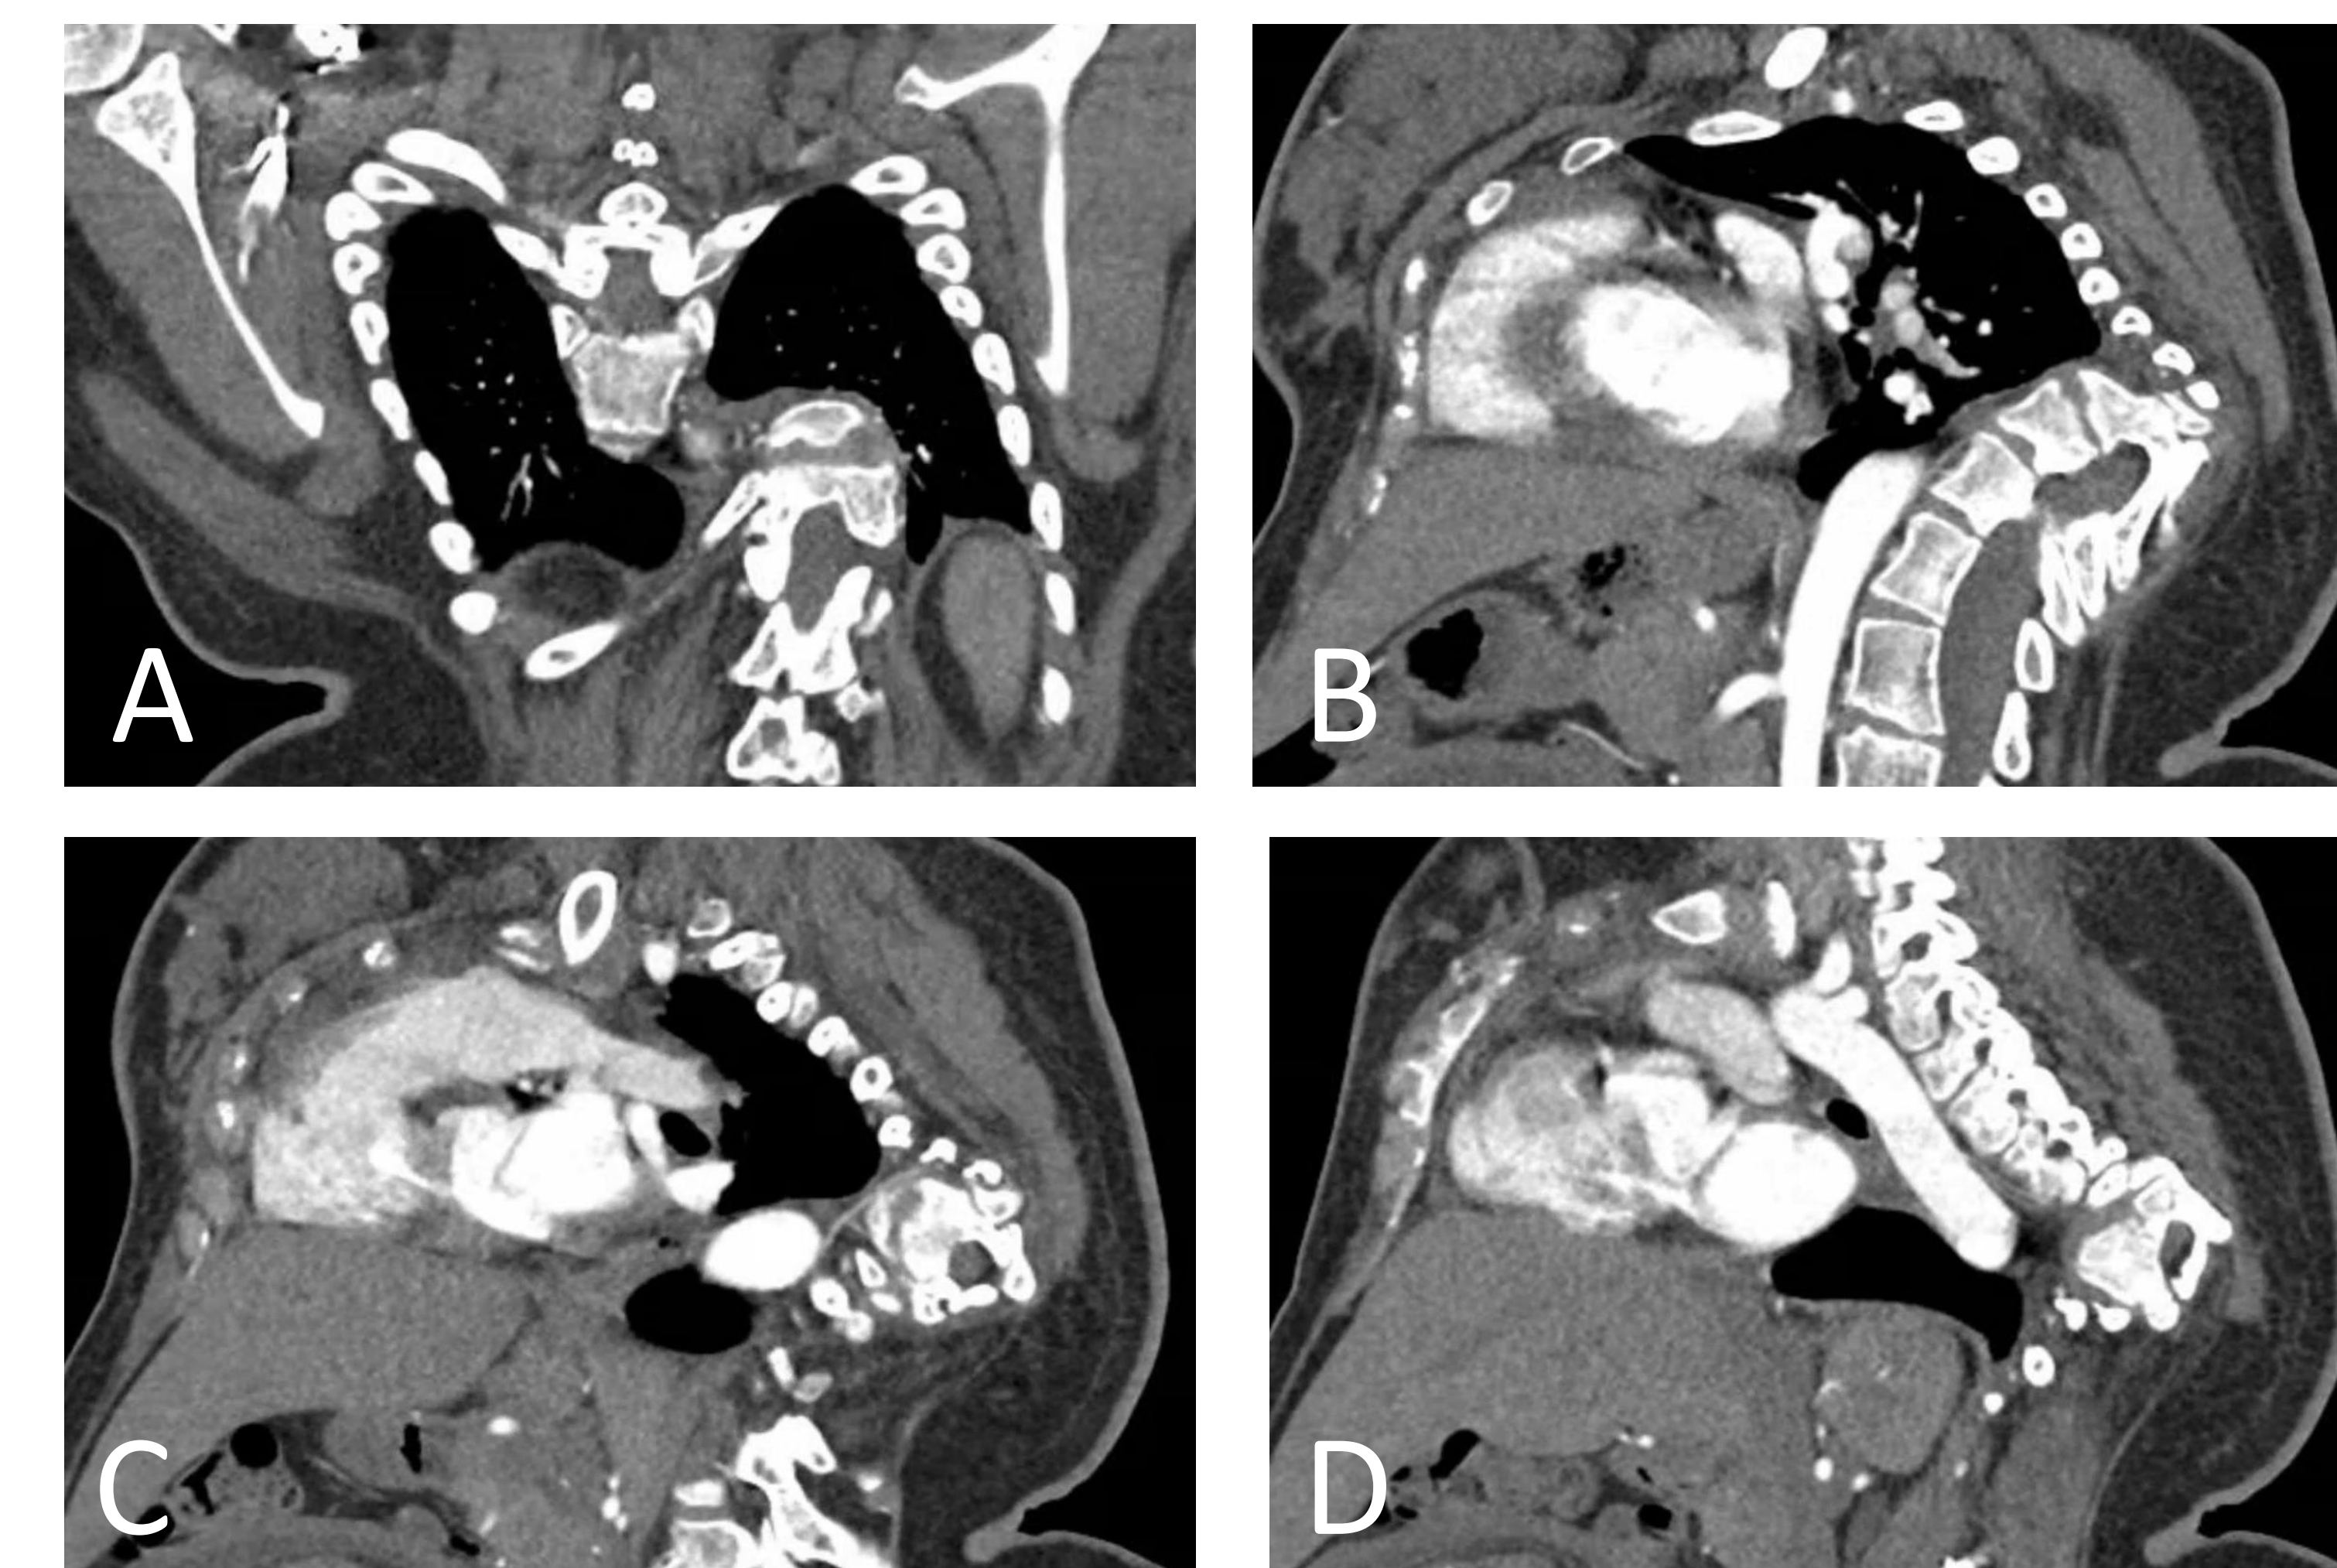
AP (A) and Sagittal (B-D) plane CT Angio Chest views demonstrating severe thoracic kyphoscoliosis in this patient.
